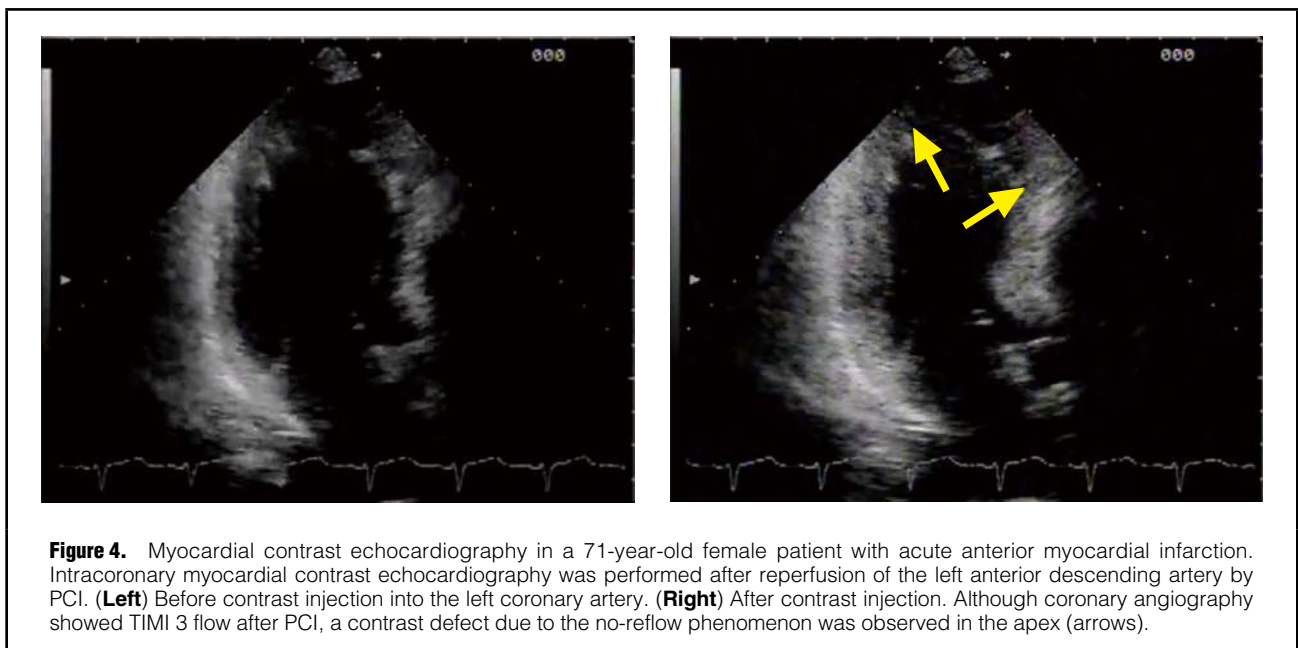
Myocardial contrast echocardiography in a 71-year-old female patient with acute anterior myocardial infarction. Intracoronary myocardial contrast echocardiography was performed after reperfusion of the left anterior descending artery by PCI. (Left) Before contrast injection into the left coronary artery. (Right) After contrast injection. Although coronary angiography showed TIMI 3 flow after PCI, a contrast defect due to the no-reflow phenomenon was observed in the apex (arrows).
